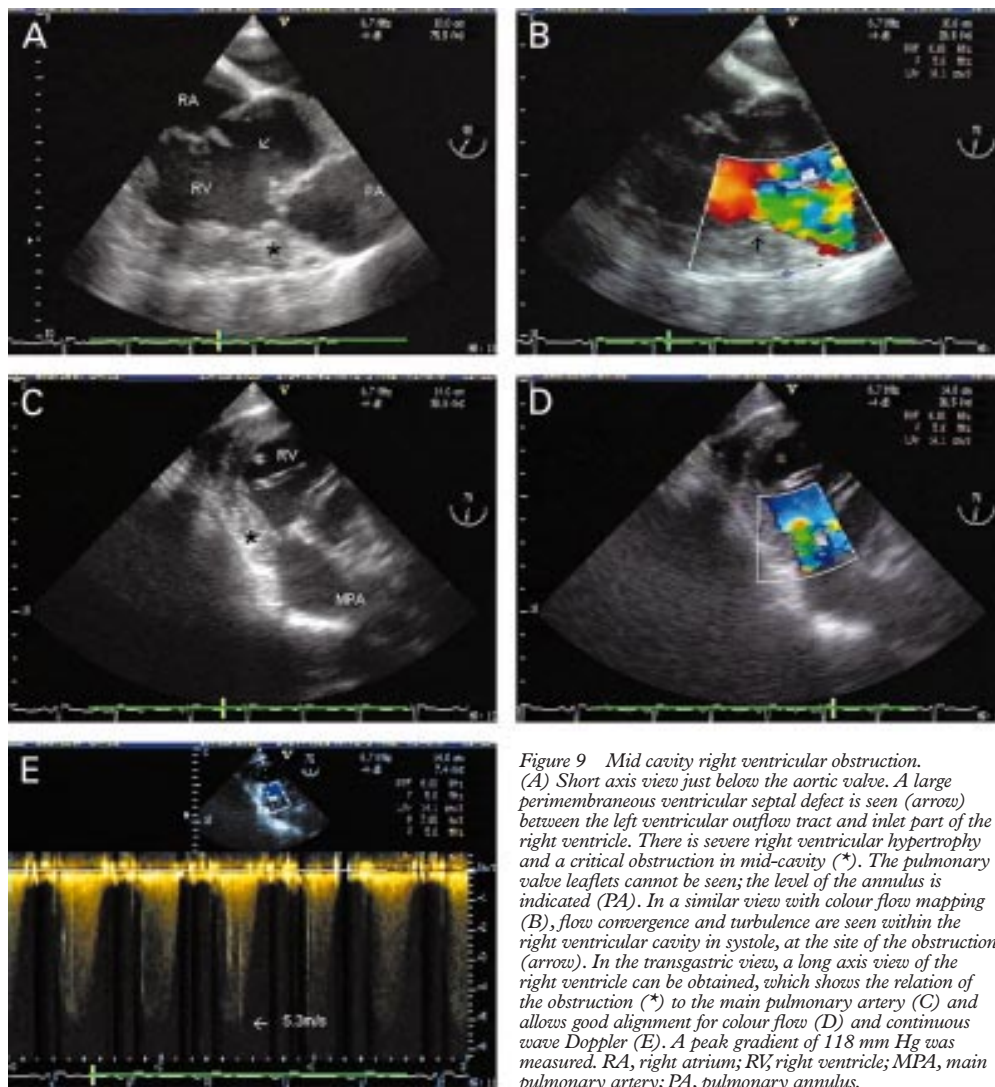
Mid cavity right ventricular obstruction. (A) Short axis view just below the aortic valve. A large perimembranous ventricular septal defect is seen (arrow) between the left ventricular outflow tract and inlet part of the right ventricle. There is severe right ventricular hypertrophy and a critical obstruction in mid-cavity (*). The pulmonary valve leaflets cannot be seen; the level of the annulus is indicated (PA). In a similar view with colour flow mapping (B), flow convergence and turbulence are seen within the right ventricular cavity in systole, at the site of the obstruction (arrow). In the transgastric view, a long axis view of the right ventricle can be obtained, which shows the relation of the obstruction (*) to the main pulmonary artery (C) and allows good alignment for colour flow (D) and continuous wave Doppler (E). A peak gradient of 118 mm Hg was measured. RA, right atrium; RV, right ventricle; MPA, main pulmonary artery; PA, pulmonary annulus.
